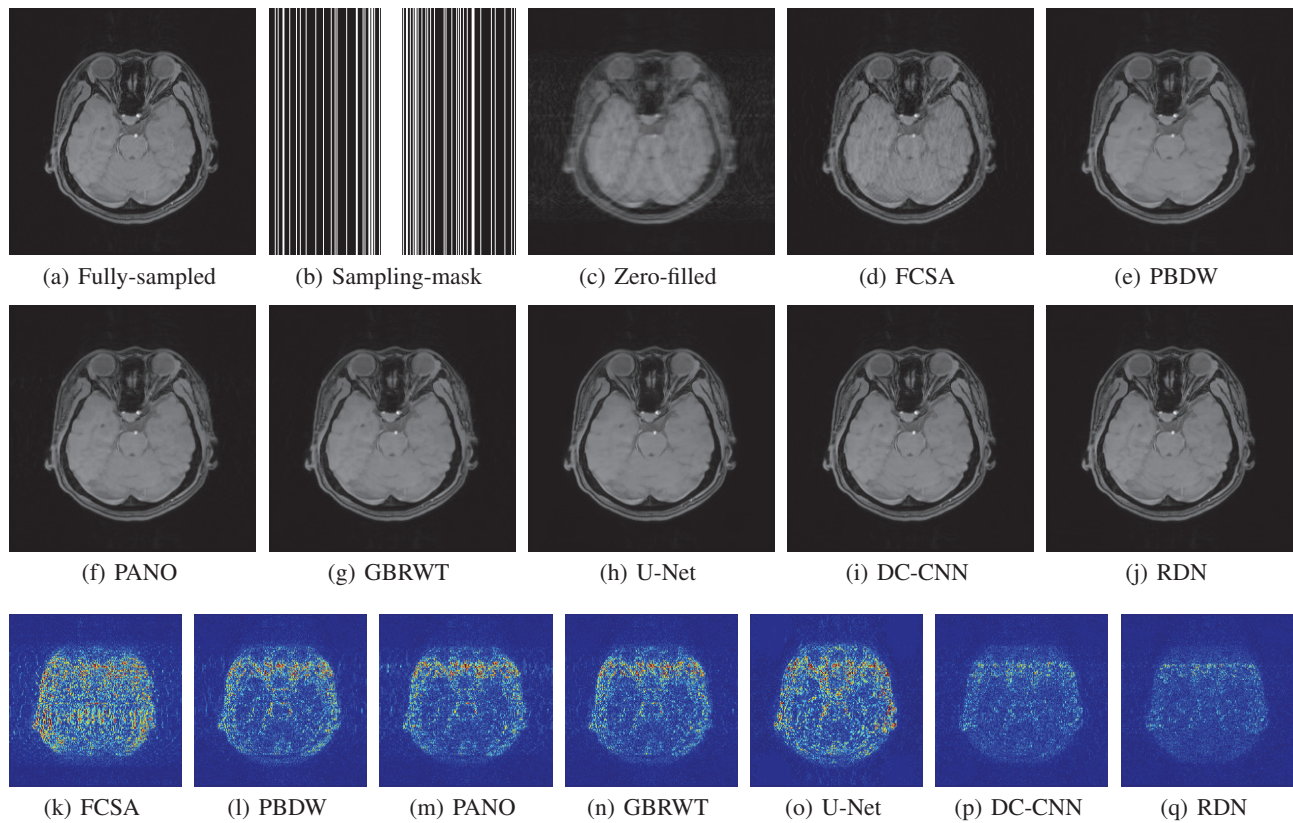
Results on a brain MRI using 30% Cartesian under-sampling.
